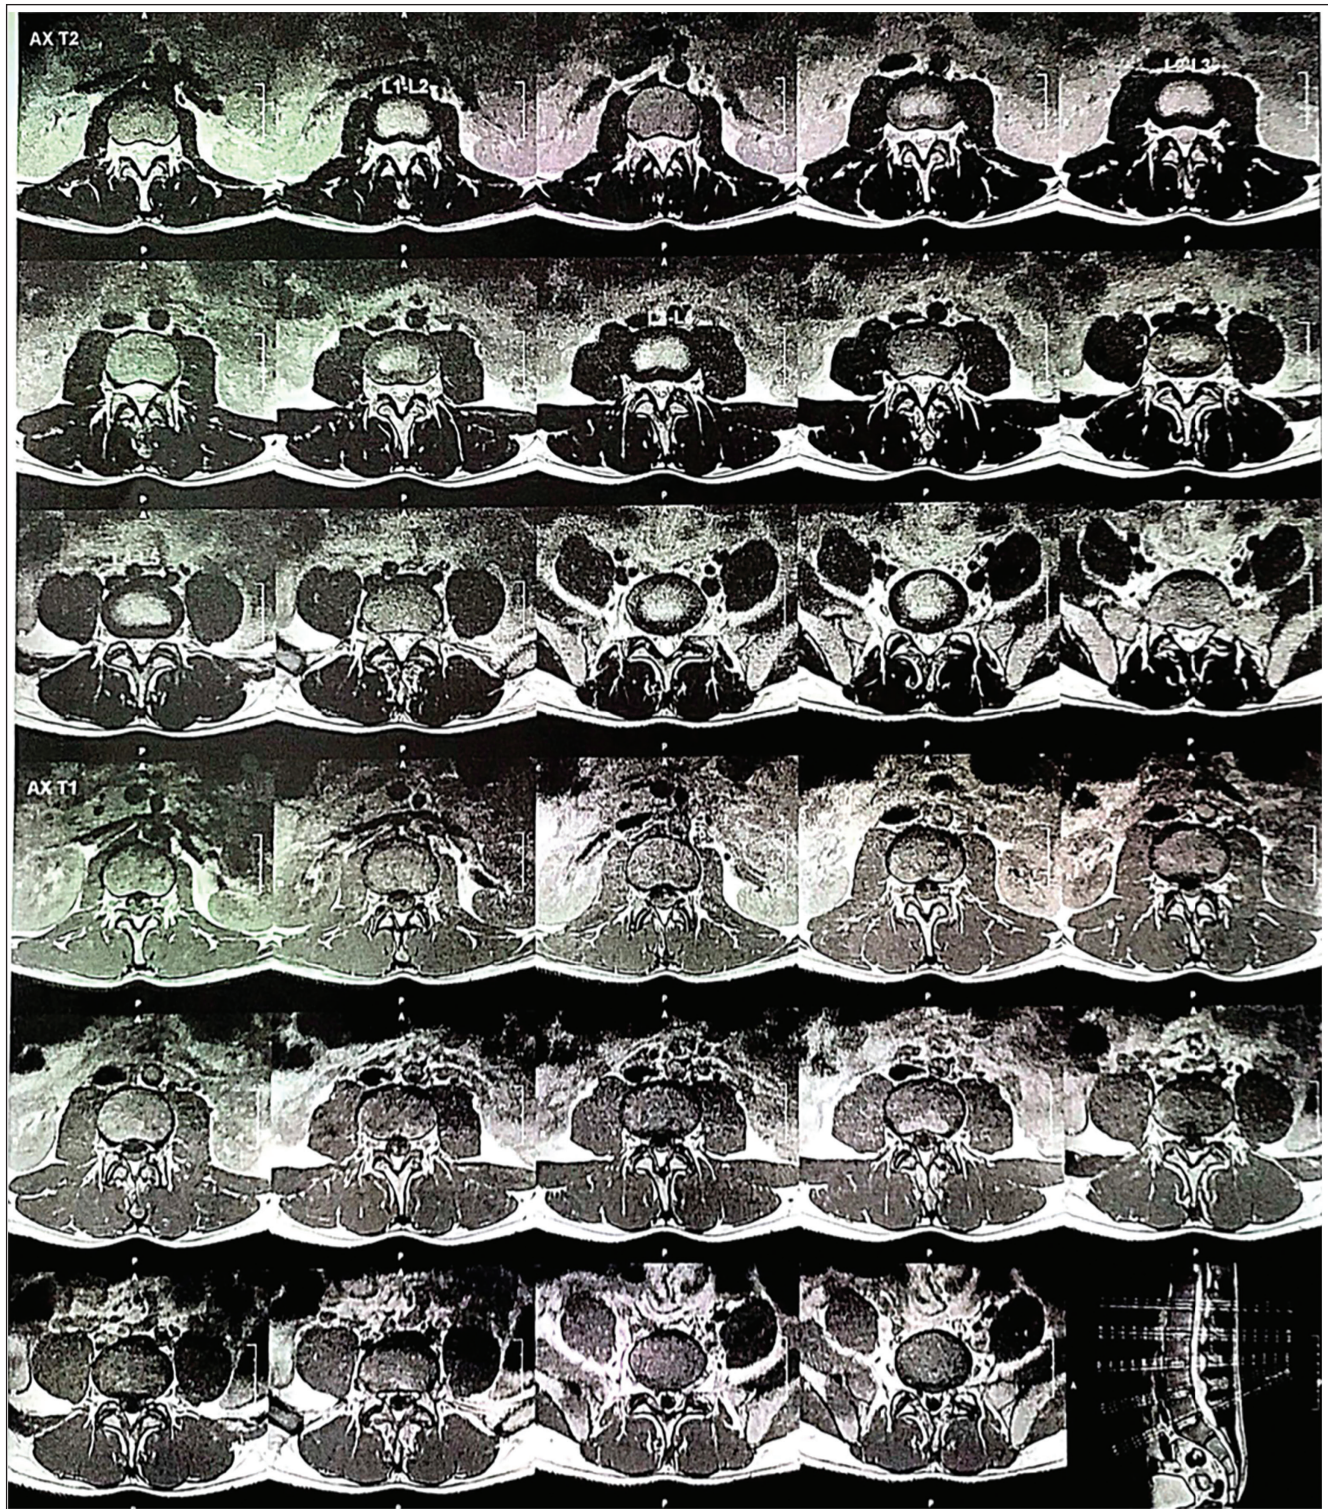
MRI Lumbar Spine Shows—Early Degenerative Changes in the Form of Diffuse Disk.
